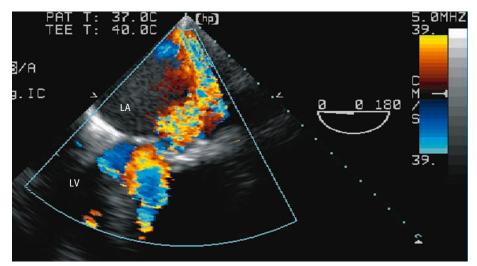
Color Doppler evaluation is the mainstay for grading the severity of mitral regurgitation. Both the width and the length of the regurgitant jet in the left atrium (LA) should be assessed. LV: left ventricle
